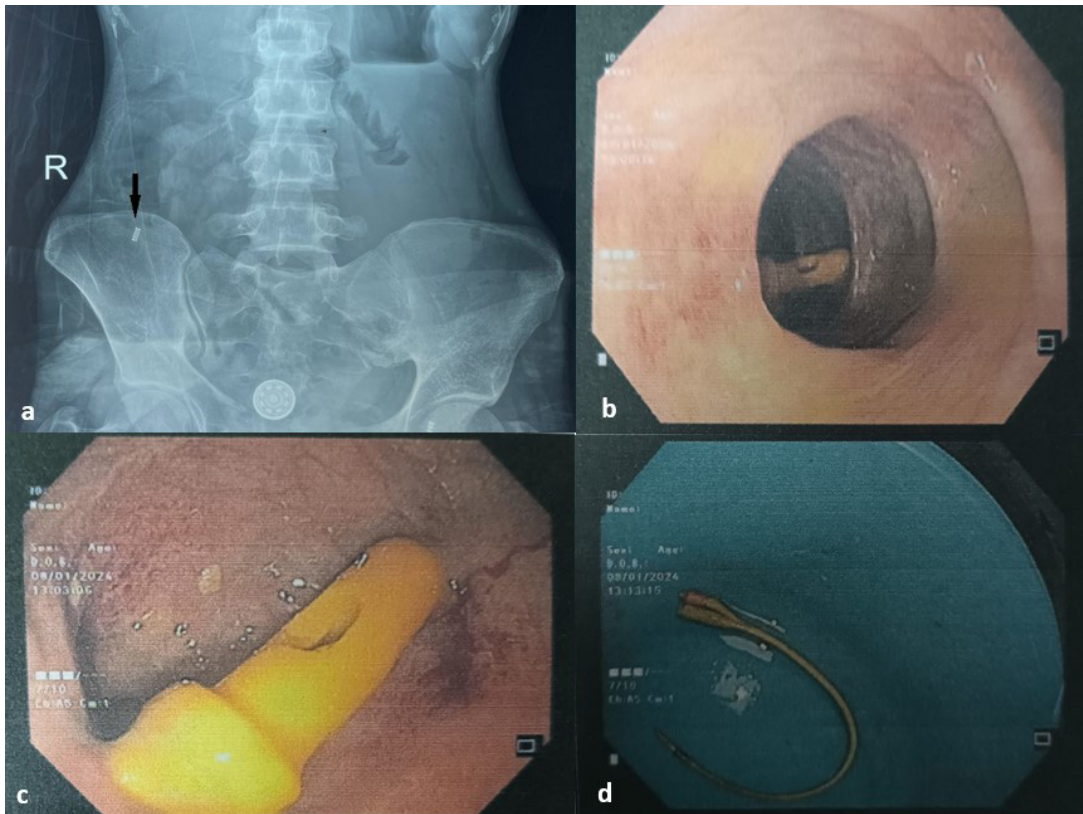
(a) Abdominal radiograph showing the mechanical spring coil of Foley's catheter in the right lower quadrant of the abdomen (Arrow) (b, c) Colonoscopic image showing catheter inside ascending colon (d) Retrieved catheter
